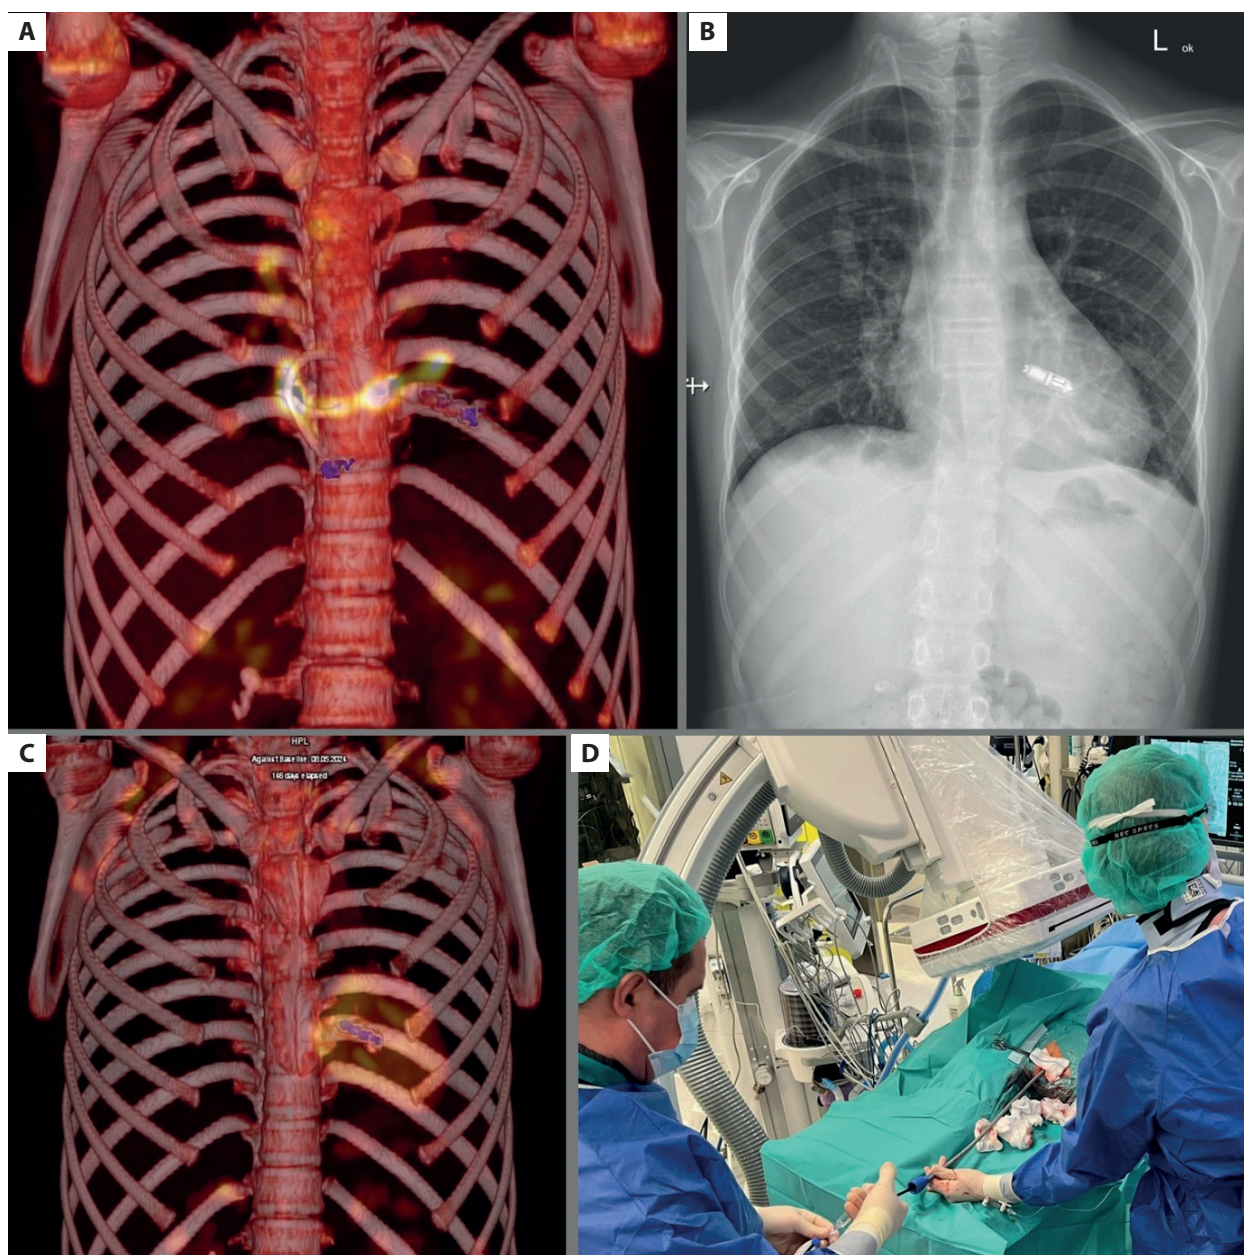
A. Positron emission tomography (PET) scan of the thorax with signs of infection spreading along the remnants of the epicardial pacing lead. B. X-ray of the thorax in the postero-anterior view with a leadless pacemaker implanted in the right ventricle. C. PET scan of the thorax with no signs of persistent mediastinal infection after the last surgical procedure and with the leadless pacemaker visible in the projection of the right ventricle. D. Modified organization of the operating room for leadless pacemaker implantation using the right jugular approach
